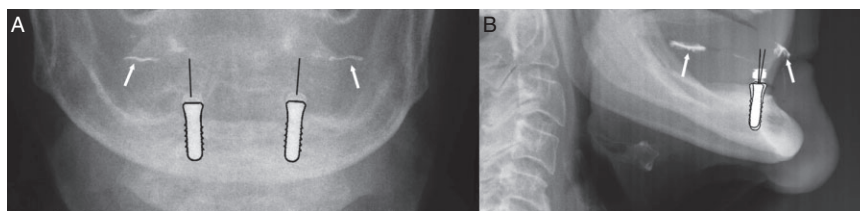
A, Coronal view of implants angulation on posterior–anterior radiograph. B, Sagittal view of implants angulation on lateral cephalometric radiograph. The dentures were marked with radiopaque material for assessment of the occlusal plane (arrows).
